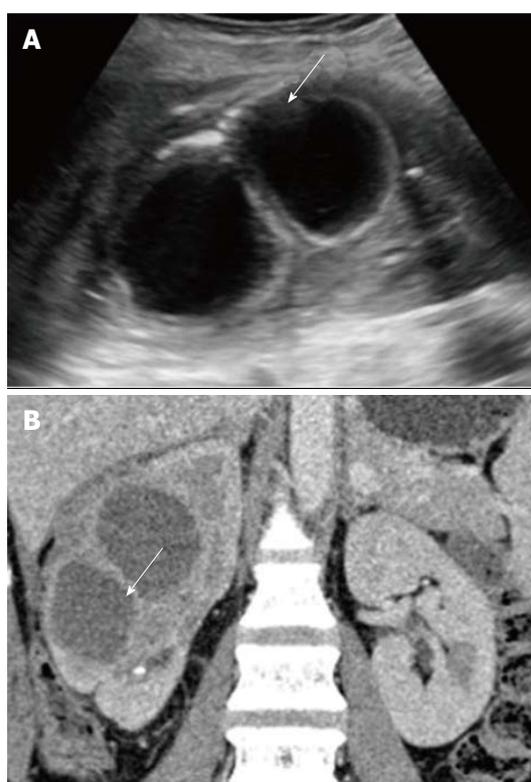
Mature abscess. A: US shows a complex cystic lesion with thick walls in right kidney; B: CECT shows a sharply marginated area of low attenuation due to parenchymal necrosis with peripheral enhancing rim that suggest a mature abscess. US: Ultrasonography; CECT: Contrast-enhanced computed tomography.
